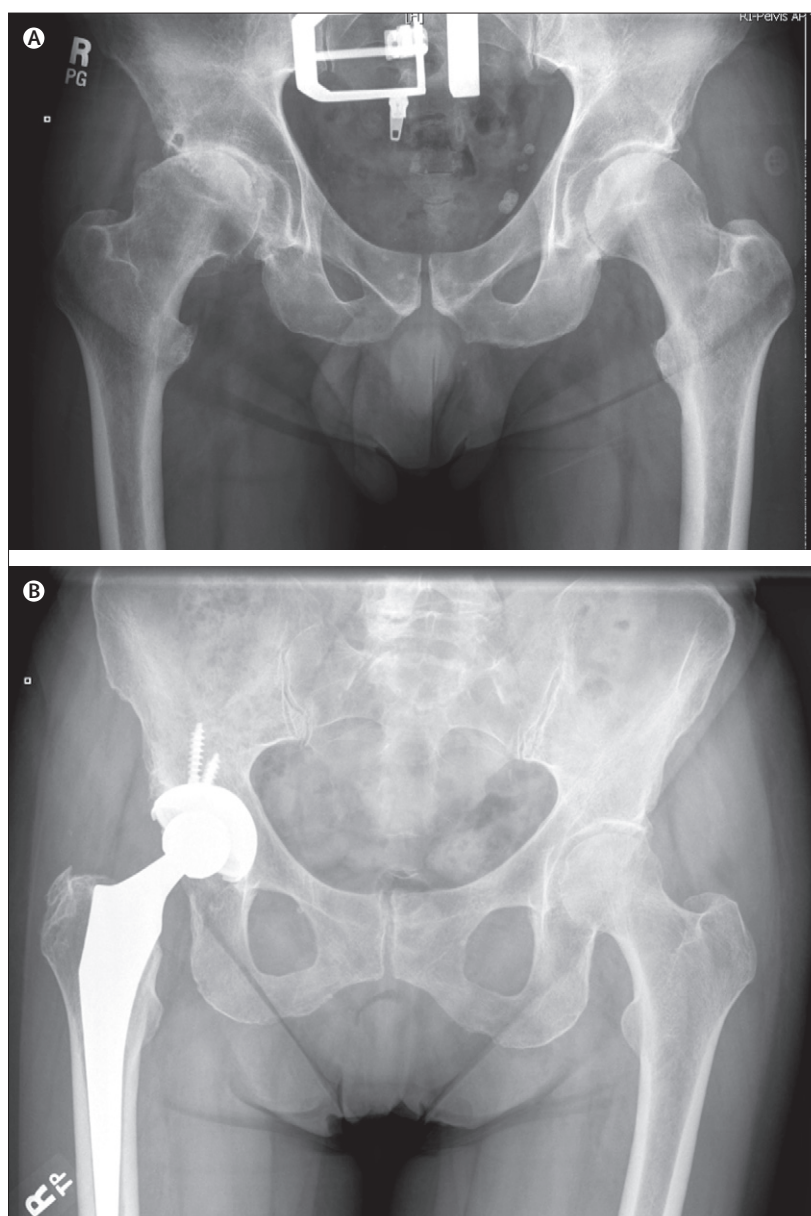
Anteroposterior radiographs of the pelvis
